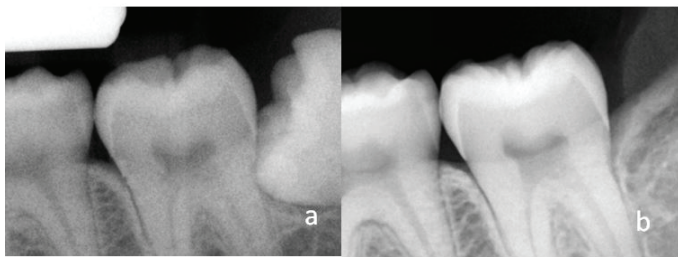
Horizontal IMP; a) Pre-operative radiograph; b) Post operative radiograph showing angular defect distal to M2 at re-assessment period.
